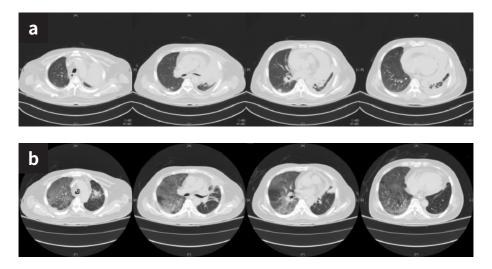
Chest CT (5a, 04-28-2017 and 5b, 05-24-2017). The left upper lobe lung cancer lesion had regressed (compared a to b), but bilateral diffusive consolidation was also noted.
